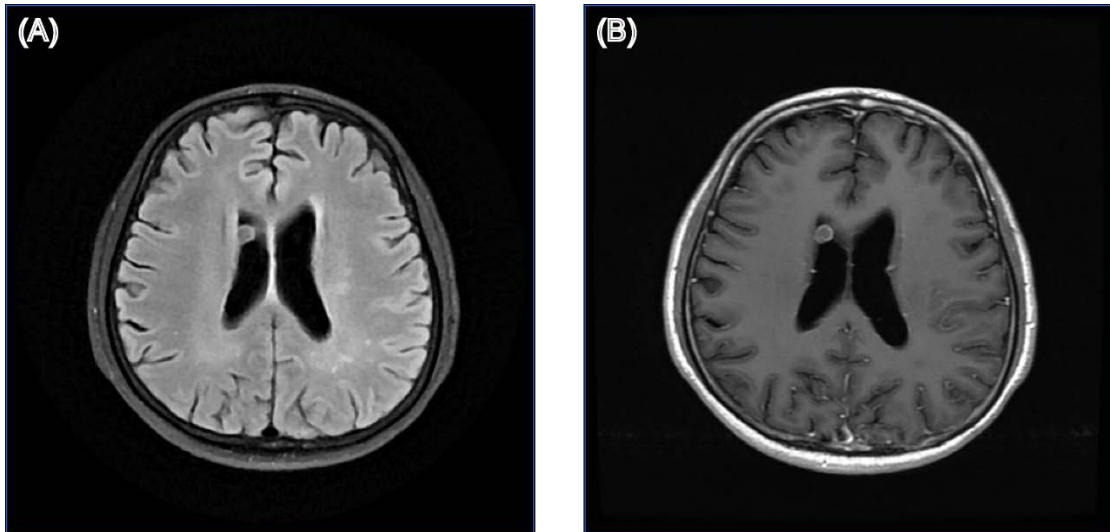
Structural brain MRI images of patient 10. (A) T2-weighted fluid-attenuated inversion recovery (T2-FLAIR) image; (B) Gadolinium-enhanced T1-weighted (Gd-T1w) image.
